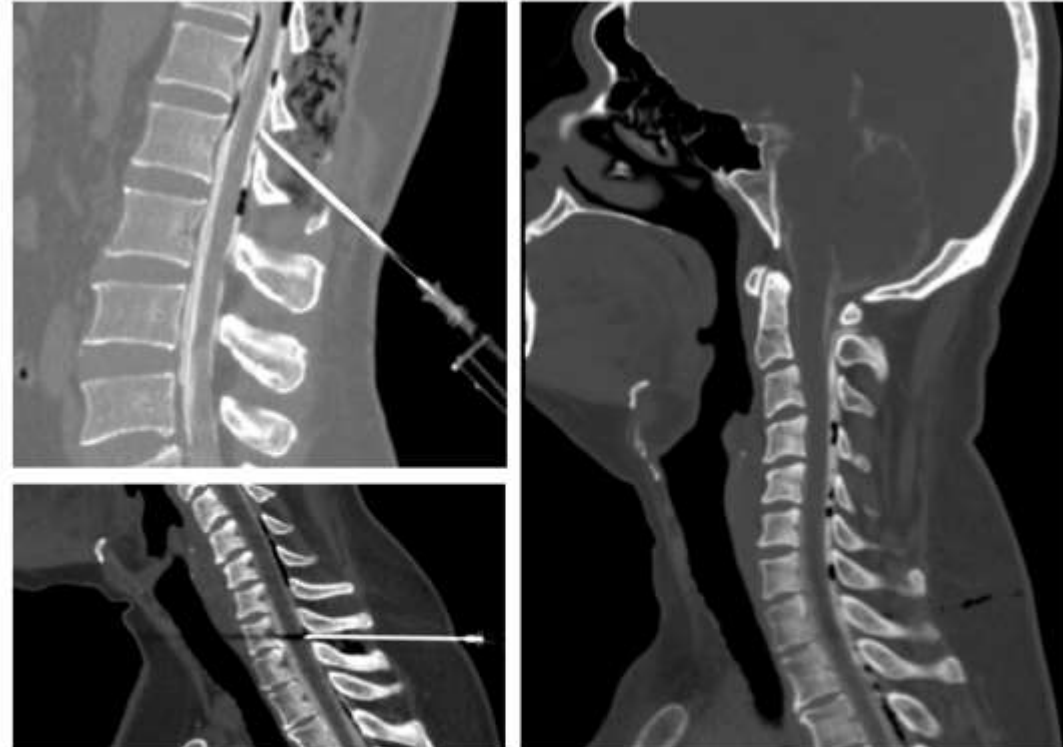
CT guided Epidural blood patch injection at the level of the identified dural tear and CSF leak
